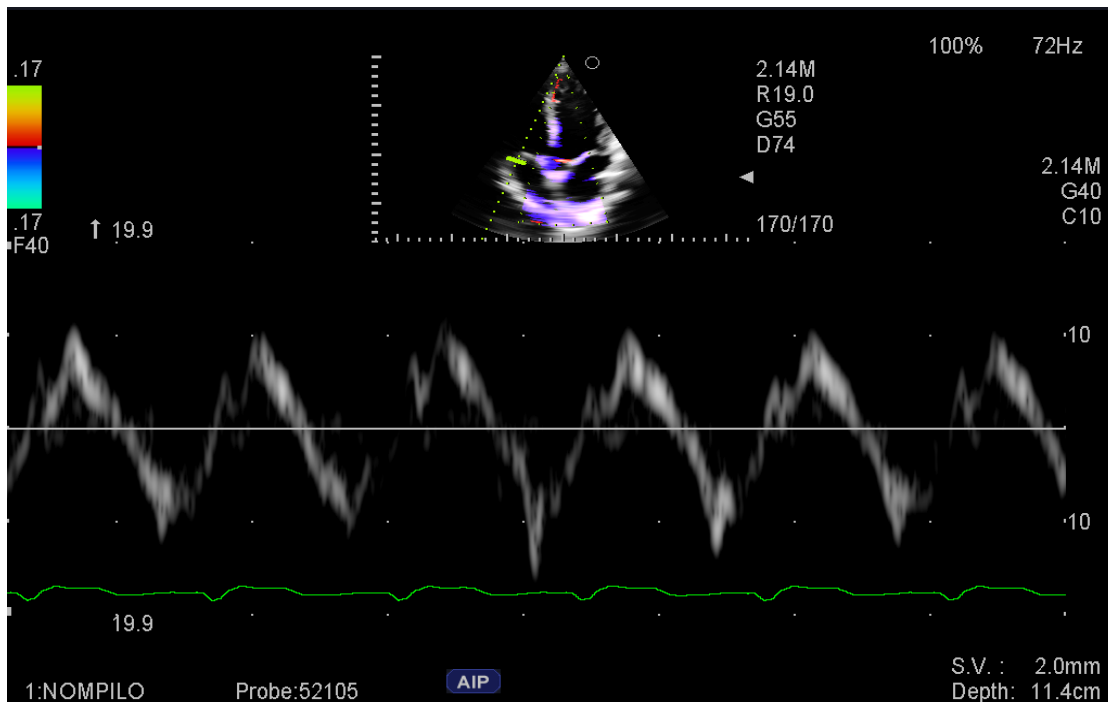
Tricuspid annular tissue Doppler imaging.
